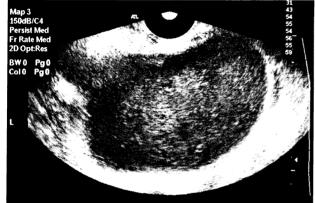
Extended pelvic inflammation threatening for the life of a patient with a ruptured tubo-ovarian abscess. Image with transvaginal ultrasonography. 3a. Ambiguous appearance of the right ovary and presence of pyosalpinx. 3b & 3c. Pyosalpinx on the left. In Figure 3c inflammatory elements can be seen around the left fallopian tube.
